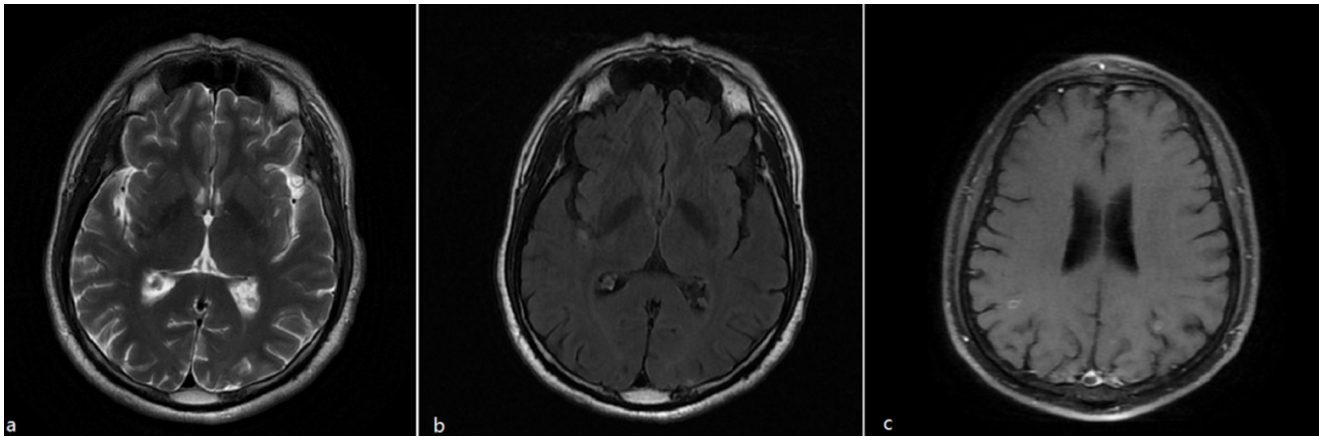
Magnetic resonance imaging at the end of treatment. All cysts were resolved on T2-weighted image (a) and Flair image (b). But a few ring-like or nodular contrast enhancements in the occipital lobe were found on gadolinium-enhanced MRI
